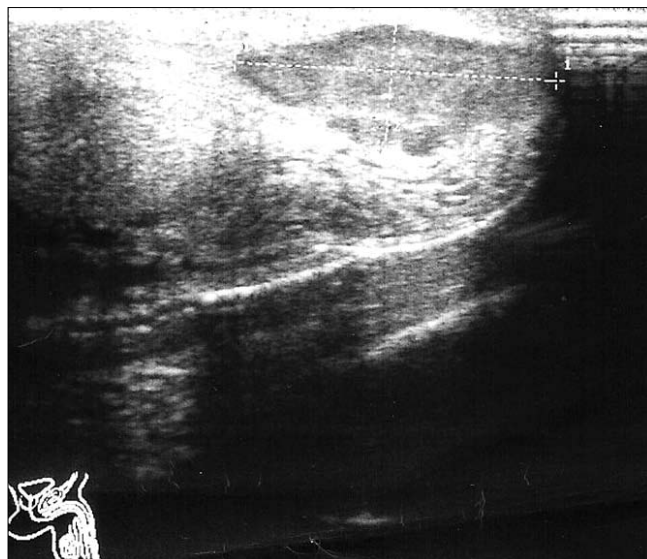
Ultrasound evaluation. Linear head of 10 MHz longitudinally placed on the penis. The glans penis part of the penis is visible. Within its area, there is hypoechoic zone located in the distal segment of the urethra, within the palpable tumor location.
